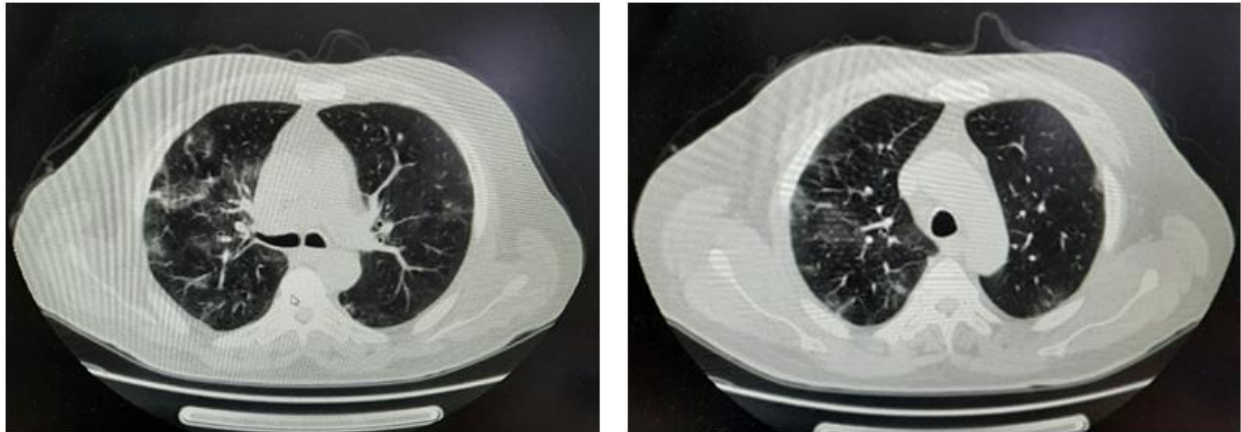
Axial pictures of CT showing bilateral ground-glass opacities
